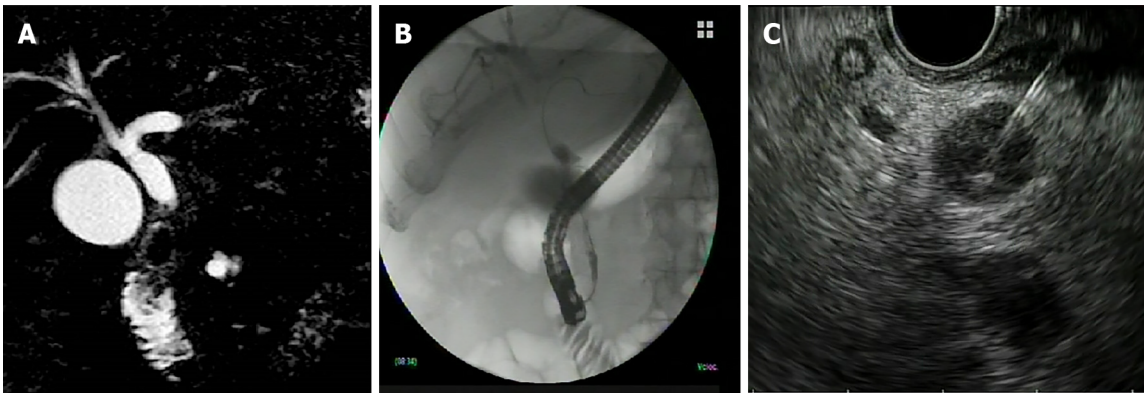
Adenocarcinoma of the main biliary tract. A: Magnetic resonance image of suspected neoplastic stenosis; B: Endoscopic retrograde cholangiopancreatography image confirming the stenosis; C: Endoscopic ultrasound-guided fine needle aspiration of the stenotic tract for tissue diagnosis.
